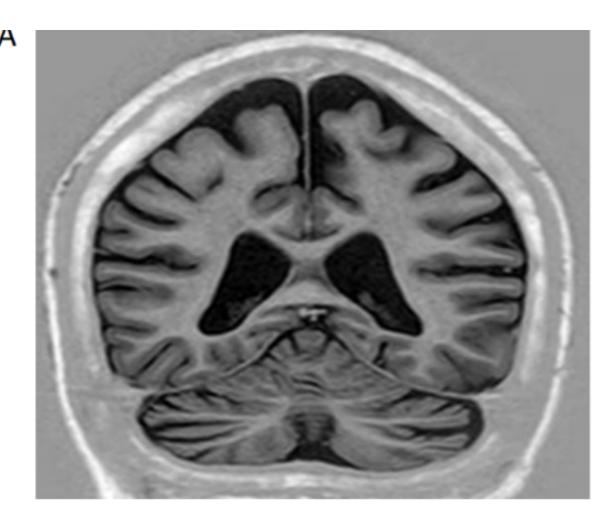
MRI of participants with NS and OAE : A) 16 yo girl with NS with global cerebral and cerebellar atrophy (T1- weighted inversionrecovery).B) 15 yo boy with NS with left temporal lobe atrophy and bilateral cerebellar atrophy (white arrow showing the temporal lobe atrophy) (T1-weighted inversion recovery).
